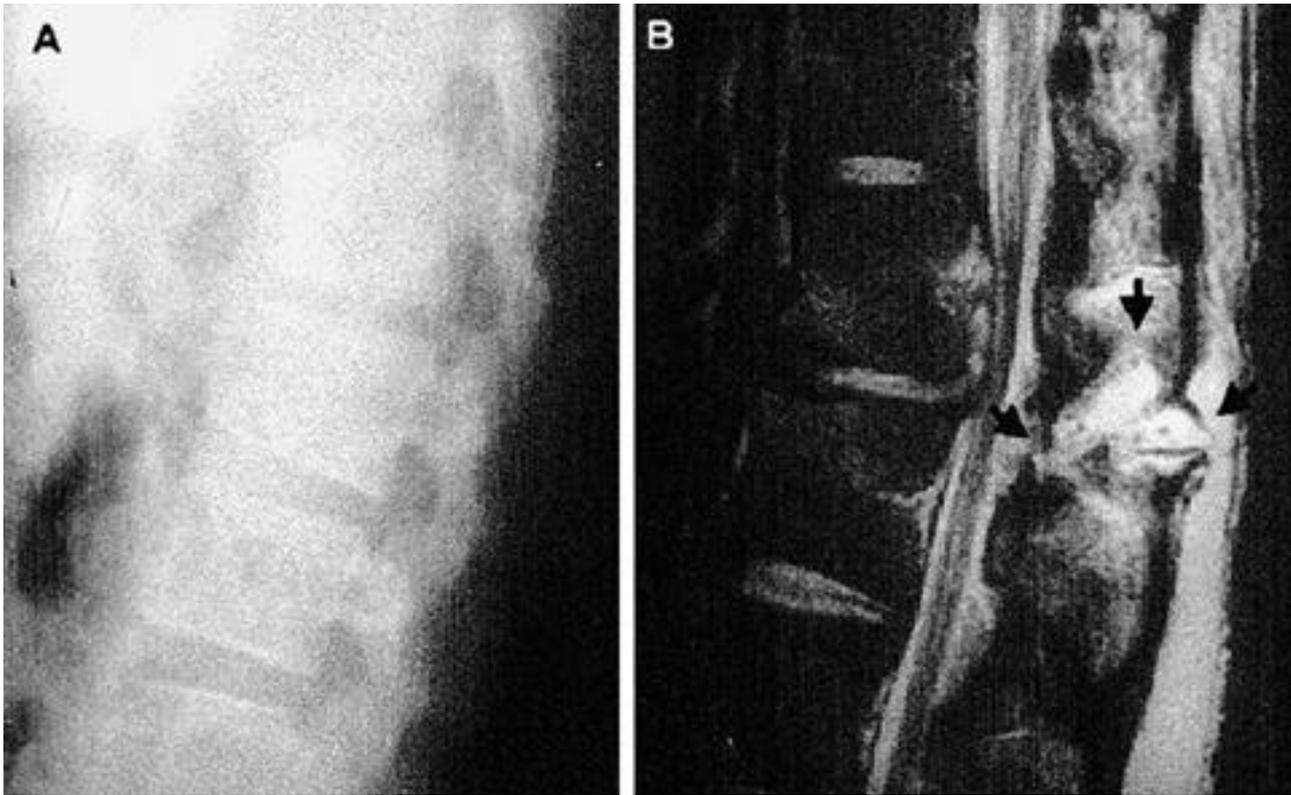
Lateral radiography of a 25-year-old man shows flexion-distraction injury of L2-3. L2-3 facet joints are distracted(A). Fat-suppressed T2-weighted sagittal sequence of MR imaging shows disruption of supraspinous, interspinous ligament, and ligamentum flavum(B).
